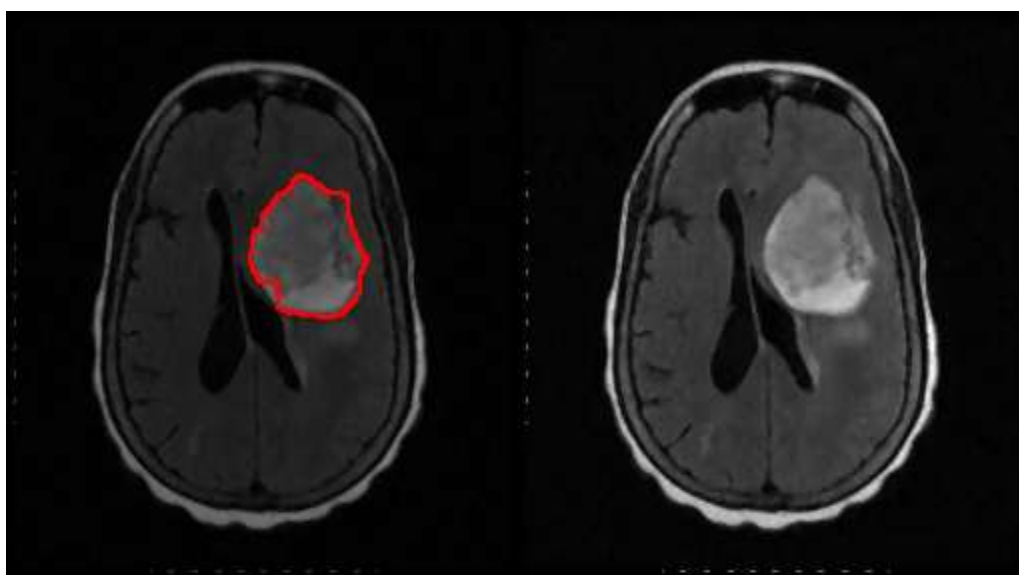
GTV of Brain Glioma Drawn at axial FLAIR images using intensity profile (left), also the volume encompasses the tumor associated edema according to (Barrette et.al (2009)).
